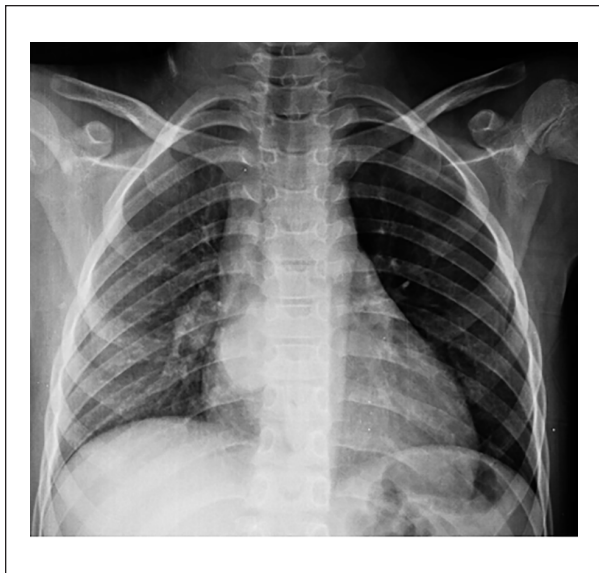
Chest X-ray: homogenous area of increased density with regular border at the right para-cardiac without cardiomegaly.
